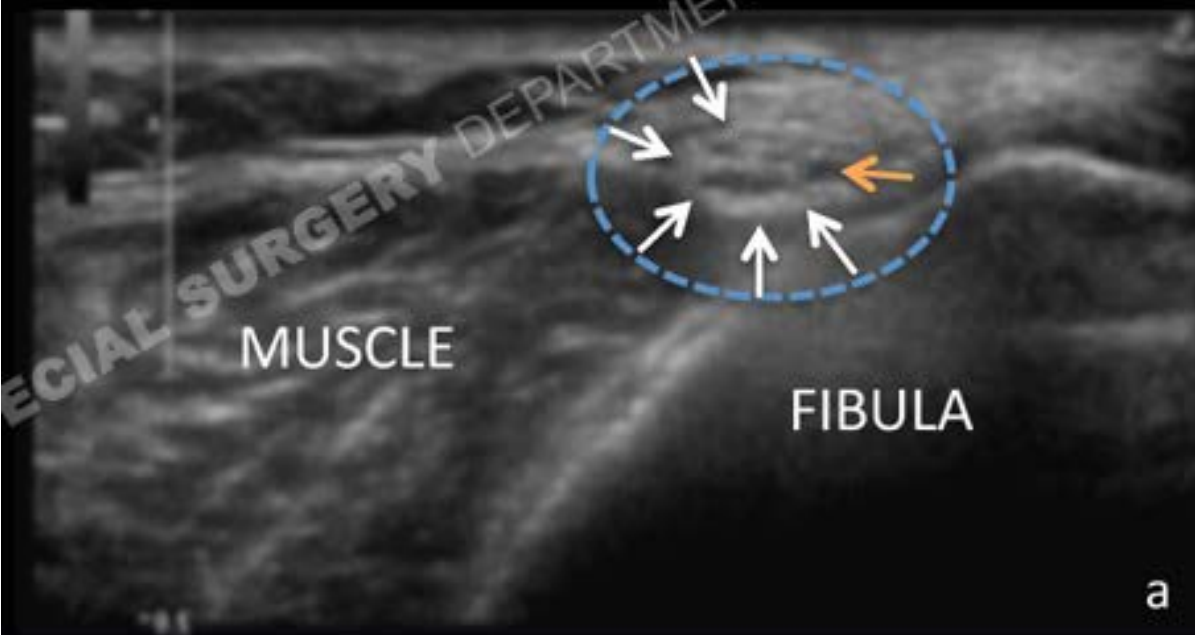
Normal appearance of the CPN on US (a) and MRI (b) at the fibular head. US image (a) at the fibular head demonstrates the adjacent CPN with peripheral echogenic/bright epineurium (white arrow) and internal hypoechoic/dark fascicles (orange arrow), a normal appearance.
